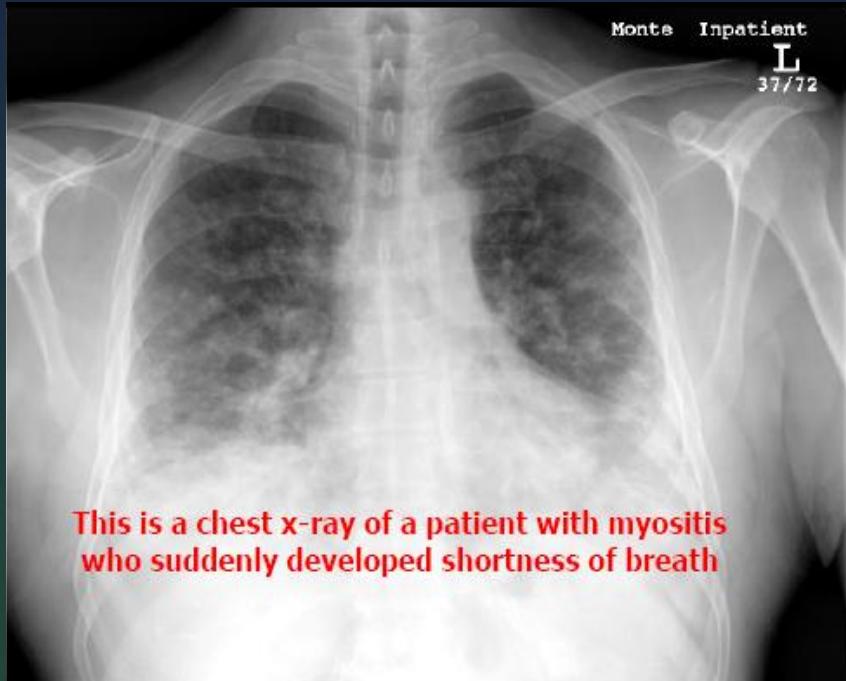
The admission chest radiograph is showing extensive bilateral alveolar and interstitial infiltrates.
